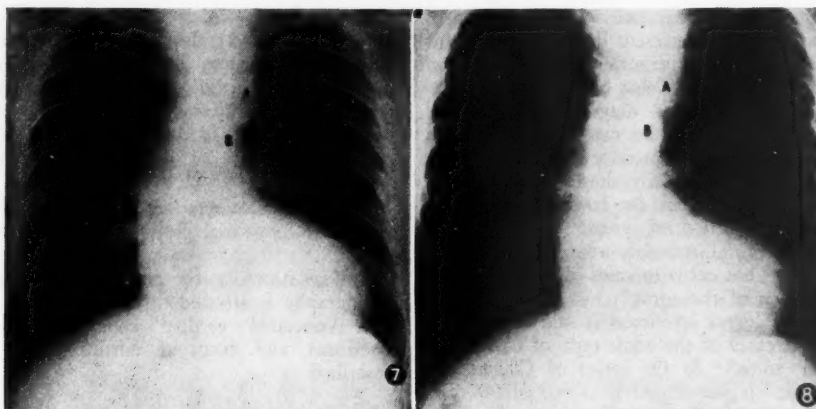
X-ray of the chest showing a false aortic knuckle (A) and a double density (B). Note also the marked rib notching and the gross left ventricular hypertrophy.
